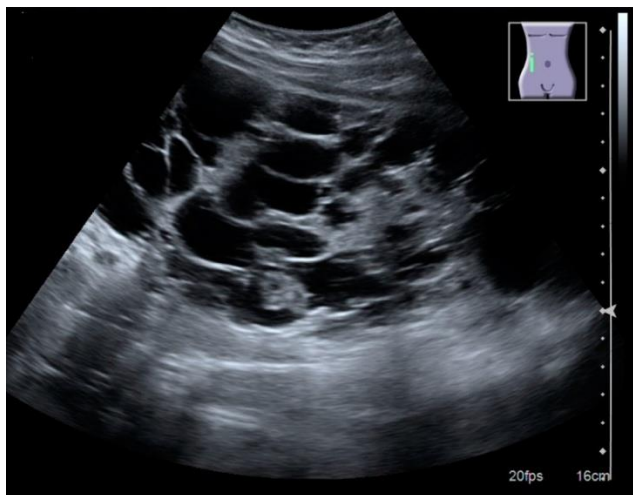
Polycystic kidney disease ultrasonography
